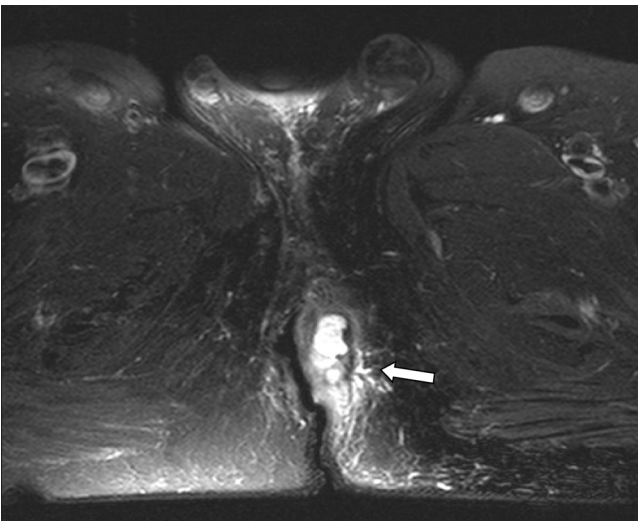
Fistula presenting in pelvic MRI.
